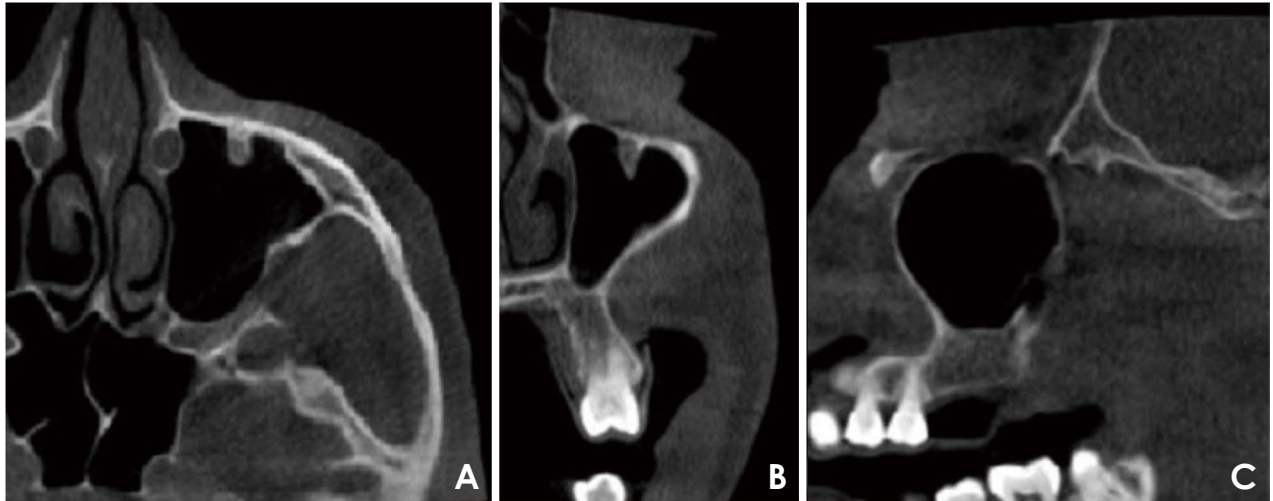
Axial (A), coronal (B), and sagittal (C) cone-beam computed tomographic images show a type 2 infraorbital canal, where the canal extends beyond the confines of the sinus roof but with no obvious sinus compartmentalization in any plane.
